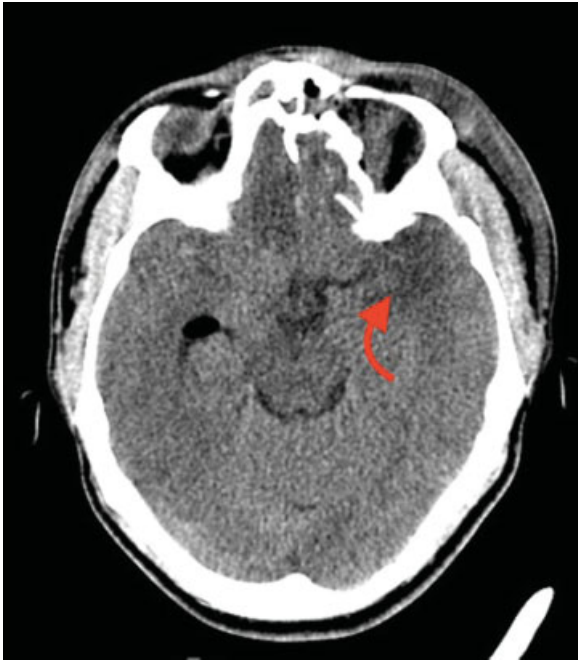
Plain CT of the brain, axial cuts, with left MCA territory infarct depicted as hypodensity noted with a curved red arrow.
